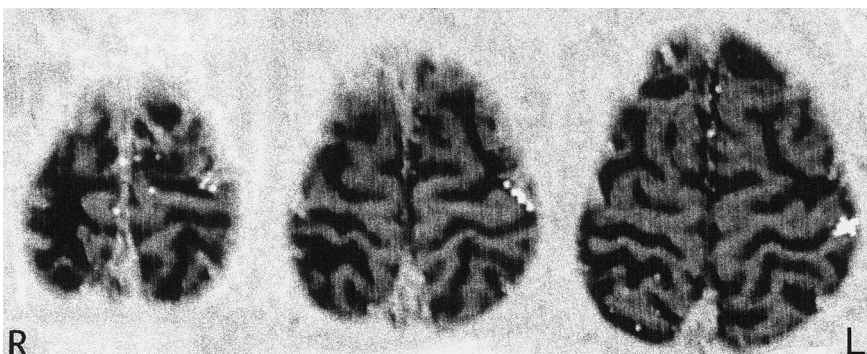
Functional MRI during motor activation. Three axial slices acquired parallel to the bicommissural plane at 4, 8, and 12 cm below the cerebral vertex are presented. Significantly activated pixels are visible on the left side during left finger movements.
